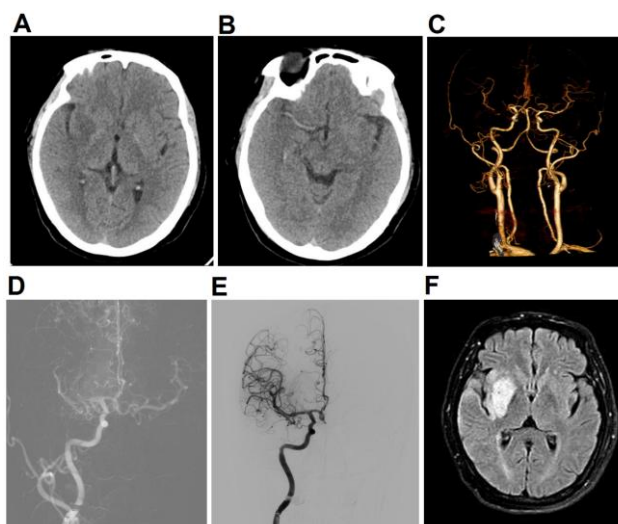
Imaging of the 3rd stroke. A. CT Scanner; B. R-MCA hyperdense; C. CTA confirmed R-M1 occlusion site; D. R-M1 re-occluded in DSA; E. 1 pass of Aspiration to archived TIC1 3; F. MRI 24h post 2nd thrombectomy
